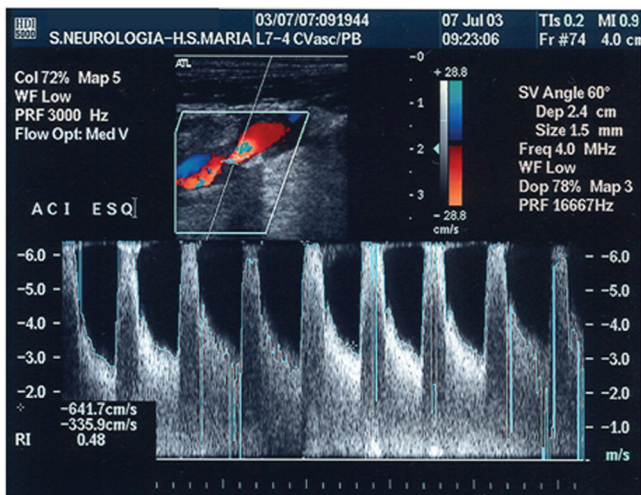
Color Duplex Scan: Internal carotid plaque causing high grade stenosis. Calcified plaque produces ultrasonic shadow. Mixed colors, meaning a turbulent flow. Blood flow velocities are depicted in waveforms.
